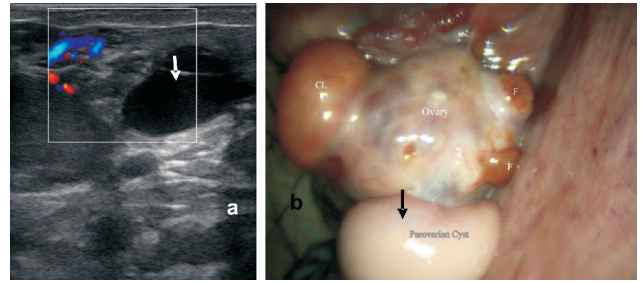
Parovarian cyst besides ovary (arrow). (a) Ultrasound image (b) Laparoscopic image.
